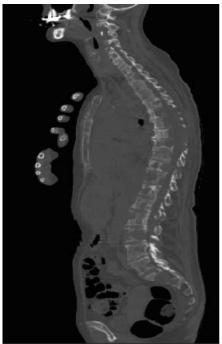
CT scan in bone window reconstructed in the sagittal plane. Tiered spinal osteolytic metastases, some of which invade the posterior wall
